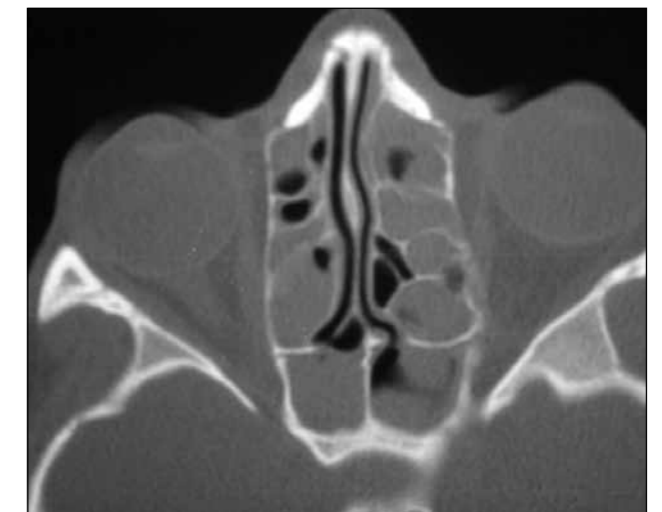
CT scan showing extensive mucous filled ethmoid sinuses.
